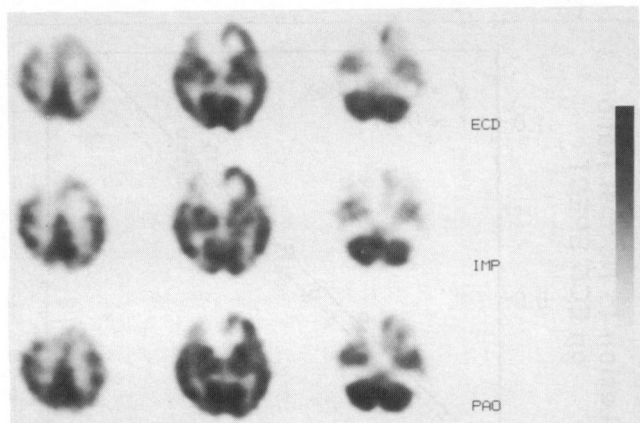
Comparison of SPECT ECD, IMP and HMPAO images in a case of chronic cerebral infarction (Patient 7). Similar images were obtained in three SPECT studies. The image contrast (lesion-to-normal contrast and gray matter-to-white matter contrast) of ECD is less prominent than that of IMP, but is better than that of HMPAO.
